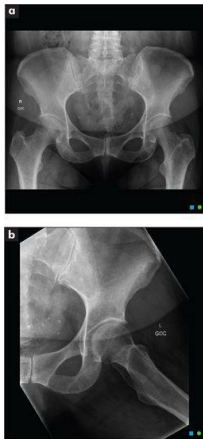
X-rays of (a) pelvis and hip joints; (b) hip in abduction
